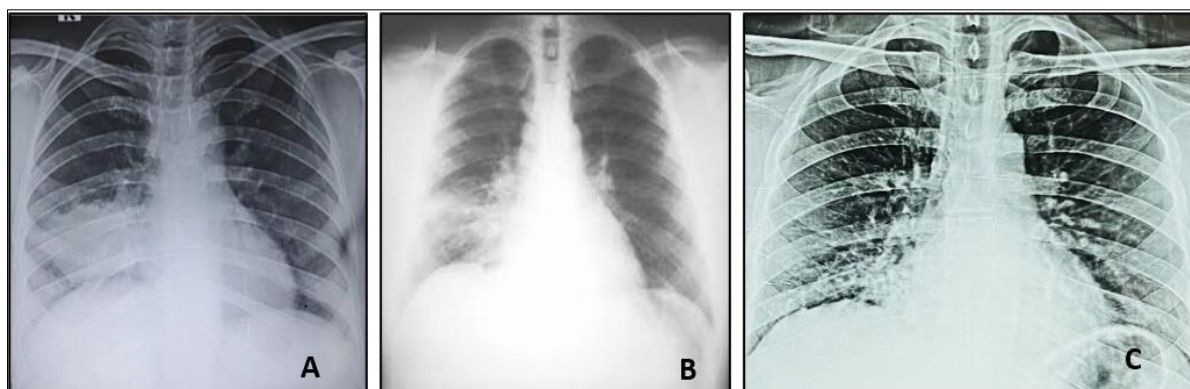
Chest x-ray posteroanterior view showing consolidation [A], Infiltrates [B] & Infiltrates with nodules [C]
